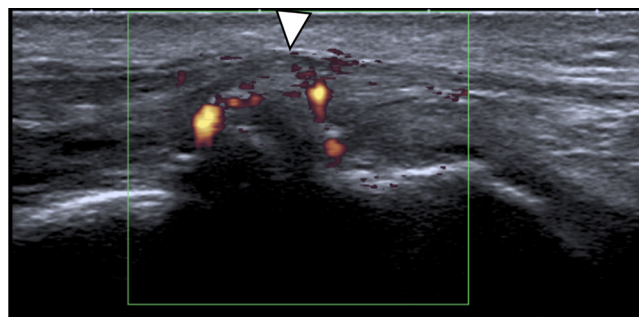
Ultrasound, coronal image with power Doppler. Lateral protrusion of femoral screw that causes impingement with the iliotibial band, with localized hyperemia (arrowhead).
